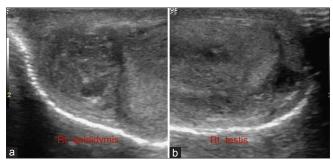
Ultrasonography scrotum: Right epididymis (a) and right testis (b) show enlarged size with heterogeneous echotexture. A hypoechoic ill-defined lesion is noted in the body of the testis. Possibility of infective etiology likely
